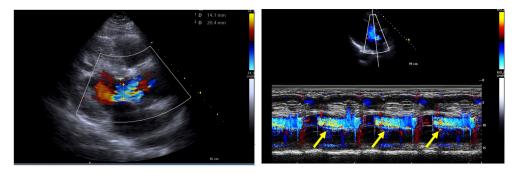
b.21. Significant holodiastolic (arrows) aortic regurgitant flow jet (parasternal long axis; left: color Doppler with evaluation of the flow jet/LVOT diameter ratio; right: M-mode and color Doppler showing the localisation of the regurgitant jet during the whole diastole)
